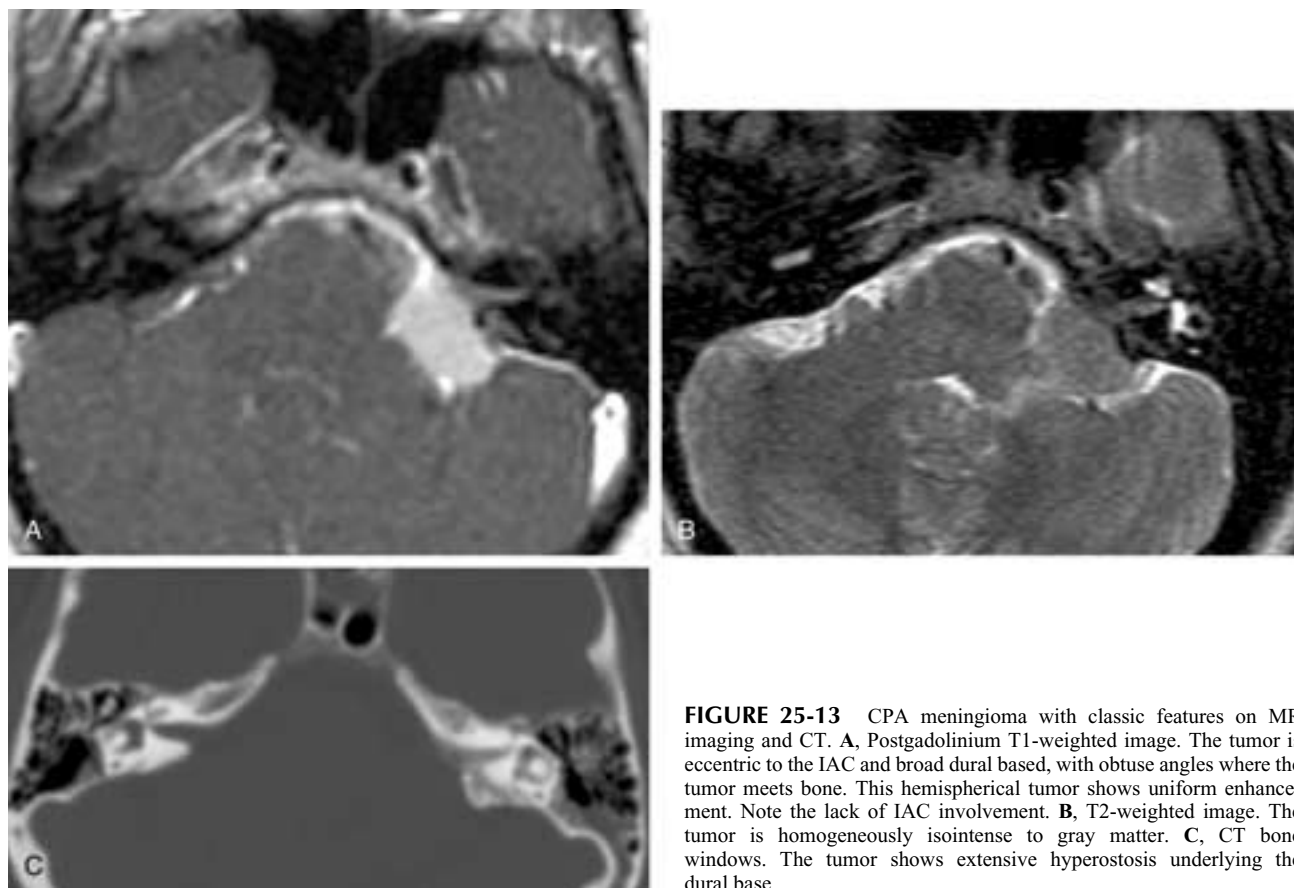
CPA meningioma with classic features on MR imaging and CT. A, Postgadolinium T1-weighted image. The tumor is eccentric to the IAC and broad dural based, with obtuse angles where the tumor meets bone. This hemispherical tumor shows uniform enhancement. Note the lack of IAC involvement. B, T2-weighted image. The tumor is homogeneously isointense to gray matter. C, CT bone windows. The tumor shows extensive hyperostosis underlying the dural base.
